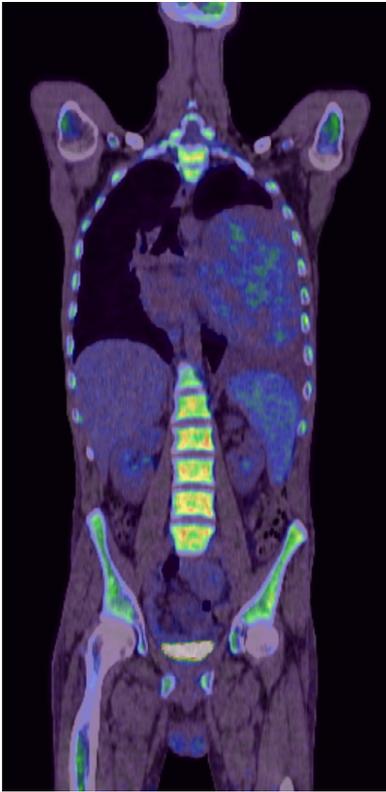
PET study post 2 cycles of chemotherapy showed reduction in size and SUV of the mediastinal mass consistent with partial response
